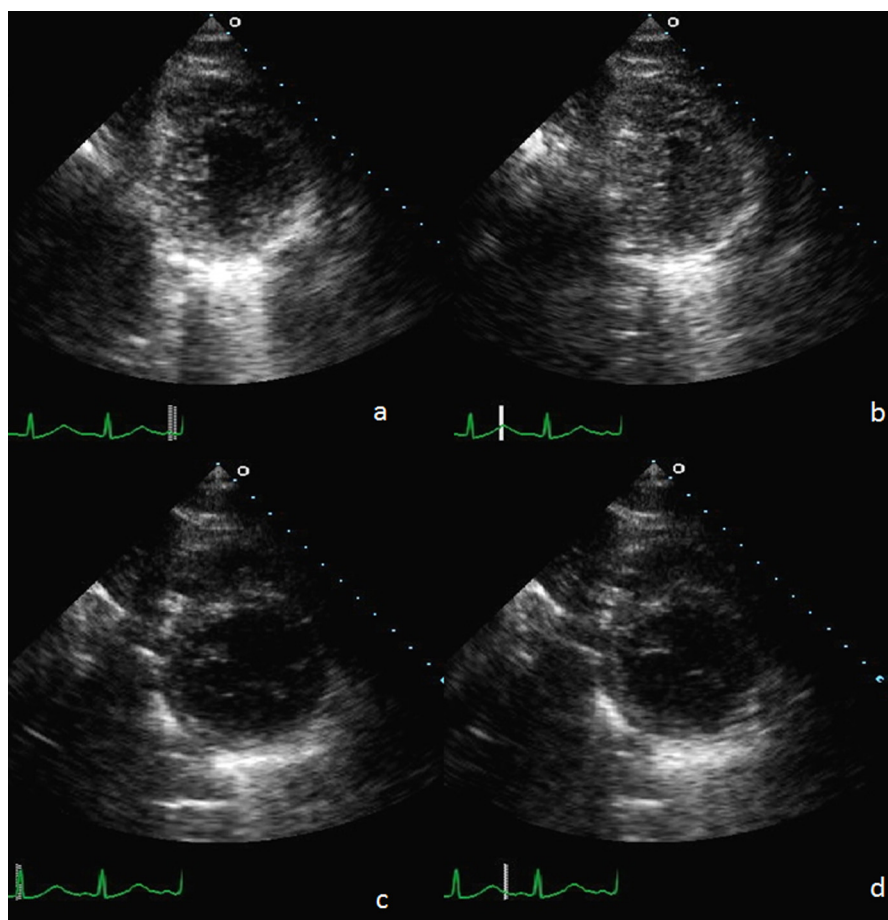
Initial echocardiograph: (a) basal short axis in diastole and (b) systole images demonstrate severe hypokinesis of the basal LV segments. (c) Apical short axis diastolic and (d) systolic images demonstrate significant change in the LV dimensions indicating hyperdynamic contractility of the LV apical segments.
